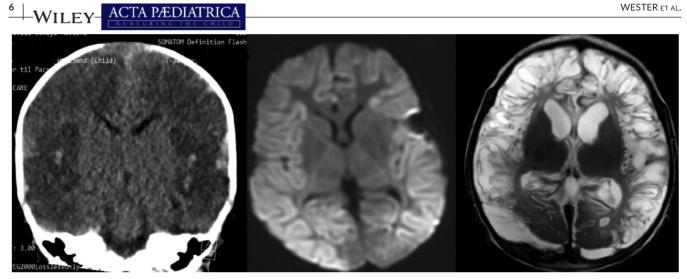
Patient #17. Coronal CT scan upon admission (left) shows widespread low attenuating areas with preserved central grey matter structures, indicating a recent event of hypoxia/ischaemia. There is also fresh blood in the subdural and subarachnoid spaces. Diffusion-weighted MR image obtained the day after admission (middle) shows extensive cortical and subcortical cytotoxic oedema, confirming hypoxic/ischaemic lesions. Right: T2-weighted image from a follow-up examination performed 3 weeks later shows widespread parenchymal loss corresponding to previous areas of hypoxia/ischaemia
